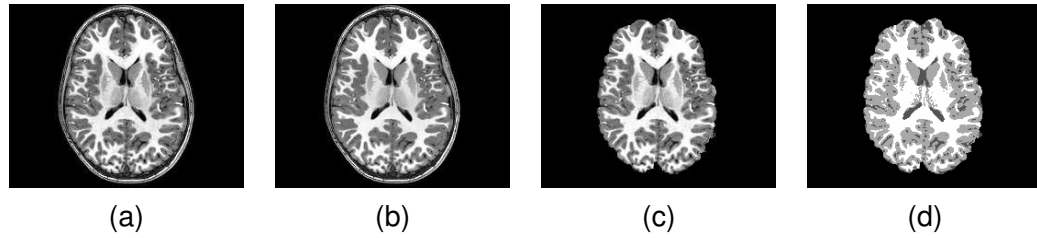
Results of applying the FSL application to a MR brain scan. Shown is an example of the (a) original MR image, (b) SUSAN processed MR image, (c) BET skull stripped MR image, and (d) FAST segmented MR image.
